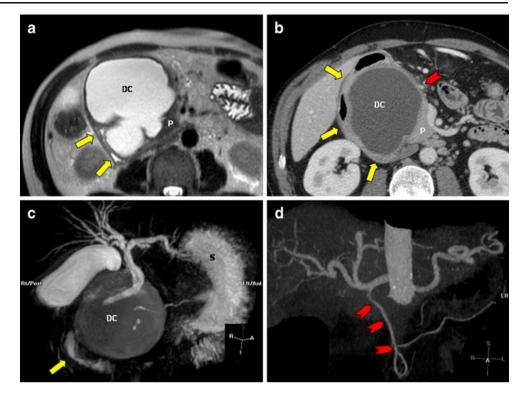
Duodenal duplication cyst. a Axial T2 WI showing duodenal duplication cyst (DC) bordered by the second and third duodenal portions (yellow arrows) and medially by pancreatic head (P). Thickwalled, well-defined cystic lesions in pancreatoduodenal groove not communicated with duodenal lumen. b Axial contrast-enhanced CT at the same level in (a). The gastroduodenal artery (red arrow) is displaced medially indicating non-pancreatic origin of the lesion. c MIP 3D MRCP reformation depicts the laterally displaced second and third duodenal portions (vellow arrow). d MIP 3D arterial CT showing the medial displacement of the gastroduodenal artery. It represents an indirect sign of non-pancreatic or duodenal origin of the lesion
